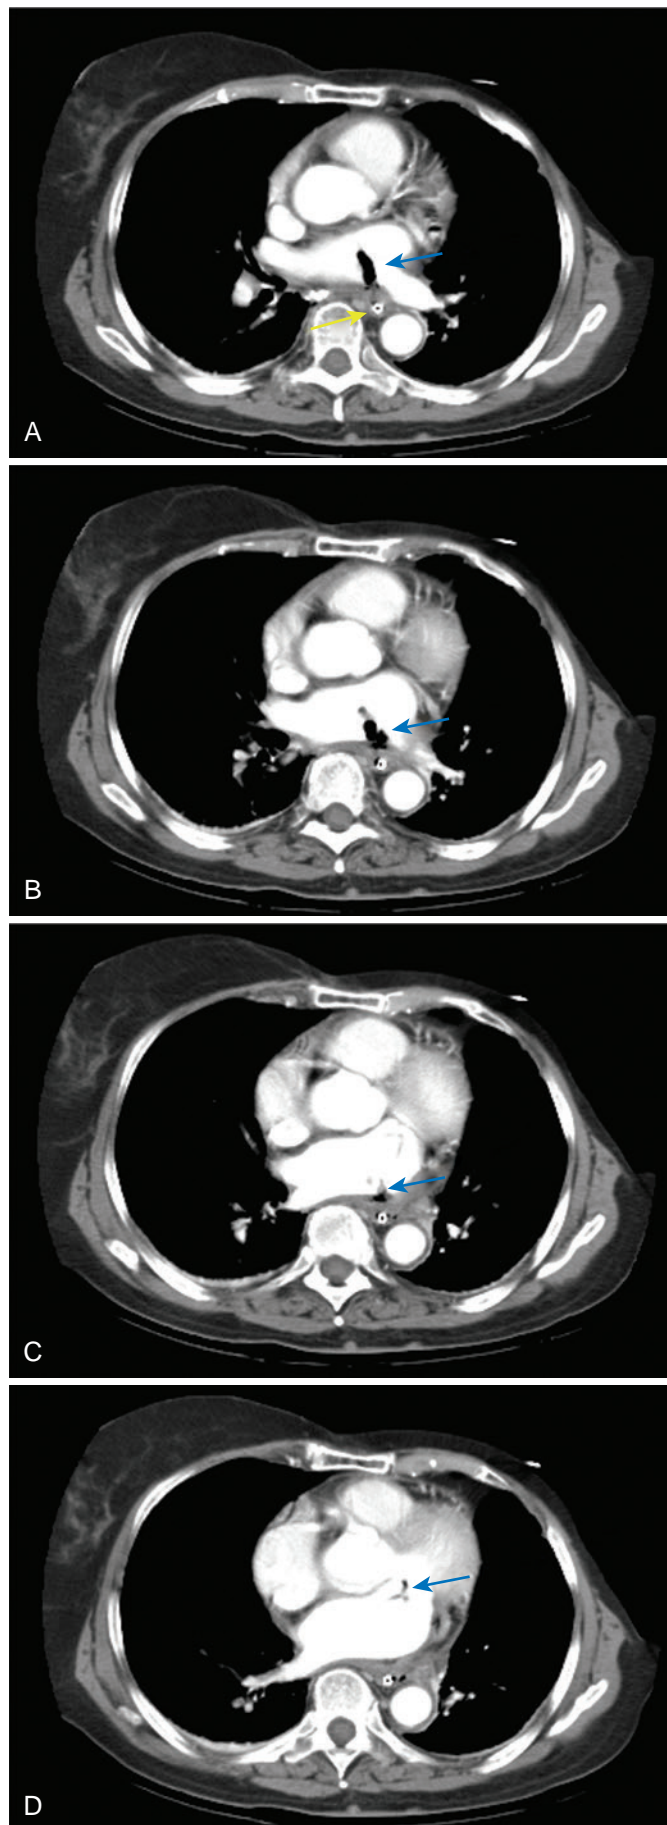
Atrioesophageal Fistula Postablation of Atrial Fibrillation. Multiple transverse sections of a chest computed tomography scan, revealing air bubbles (blue arrows) in the superior aspect of the left atrium (A–C) and at the level of the mitral valve (D). Note that air appears to originate from the anterior esophageal wall (B and C). Nasogastric tube is visualized in the esophagus (yellow arrow).
